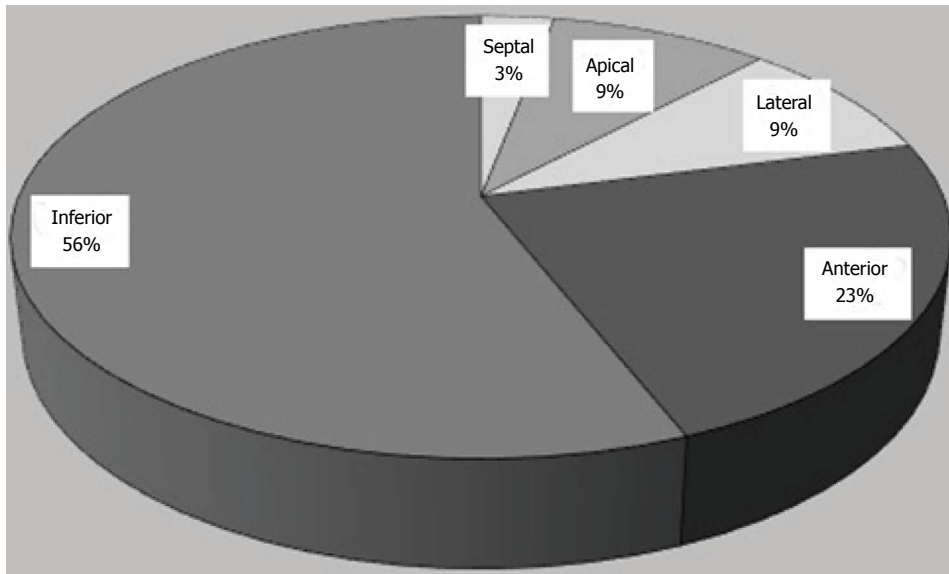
Defect location on single photon emission computed tomography myocardial perfusion imaging.
